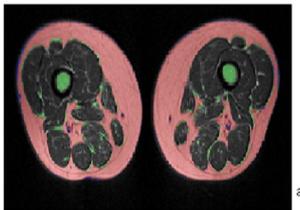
4th and 10th MRI image of human thigh in axial plane
